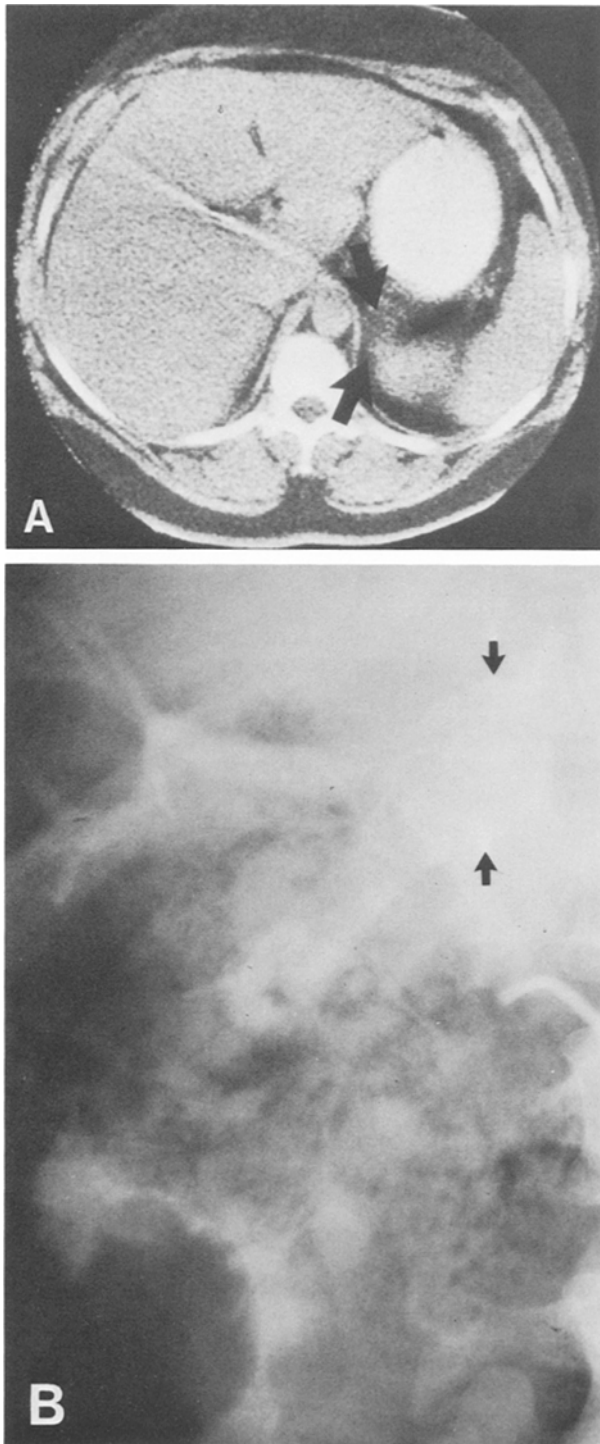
Another patient had CT scan evidence of an adrenal mass (A), but a venogram was done, which in late phase shows the mass to be cortical in location (B), and nonfunctional on further study.
